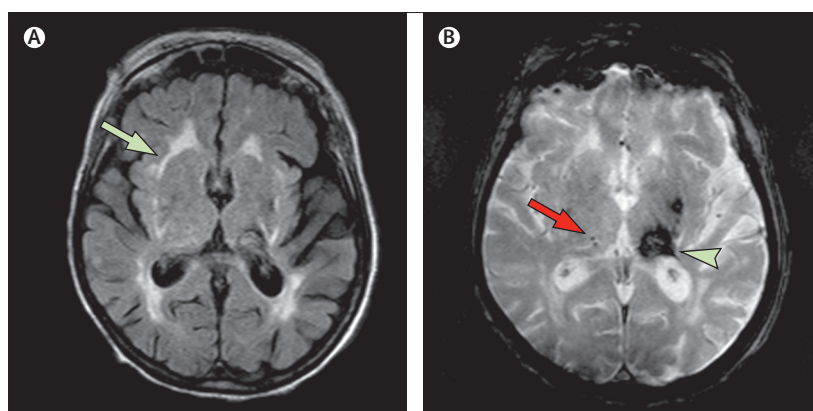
Brain MRI, axial slices
